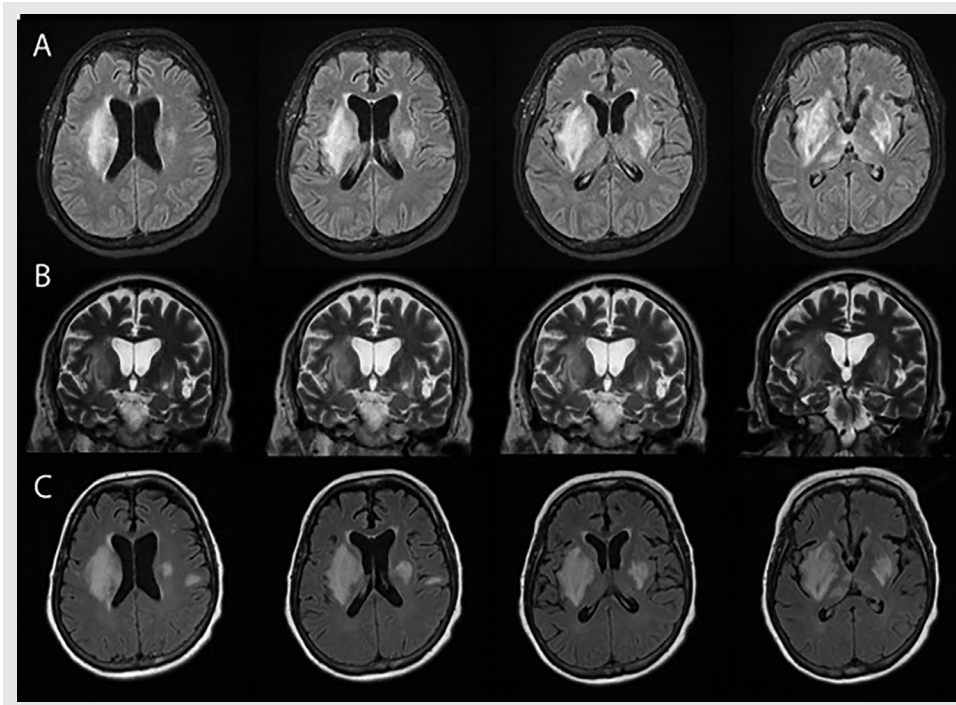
(A) and (B) Final MRI sequence (HD 23) and (C) Initial MRI (HD 2) of head.
